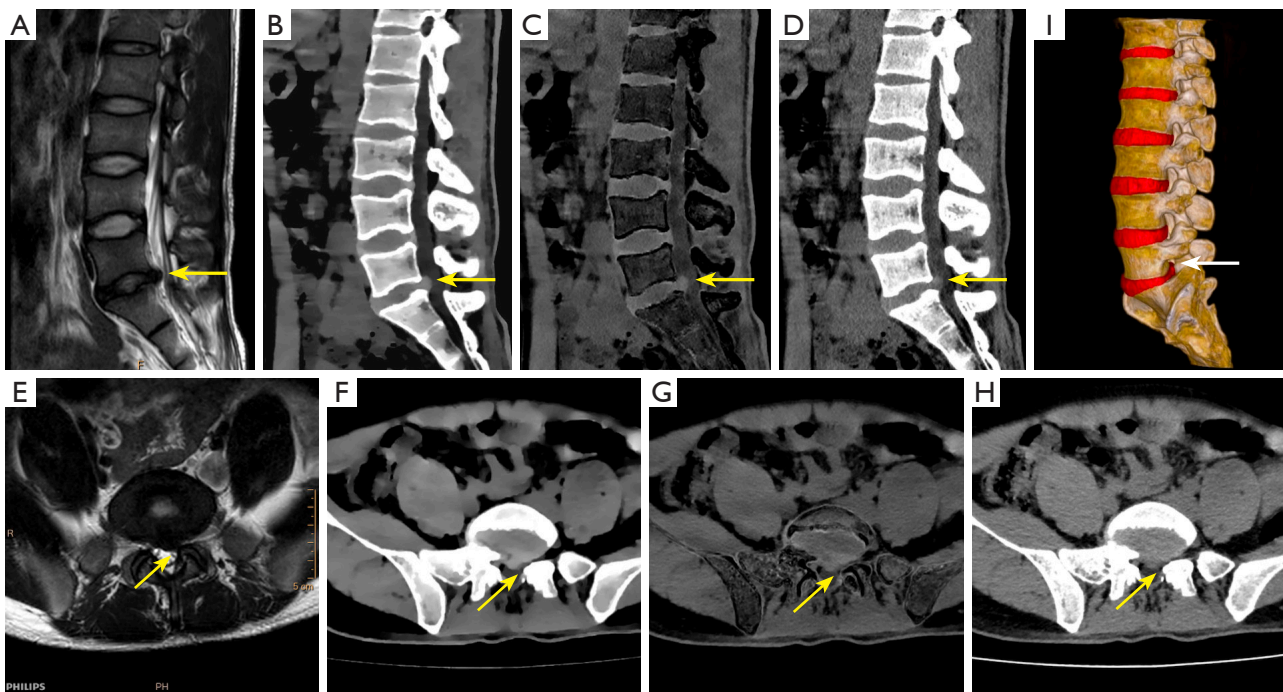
A 26-year-old male with lower back pain and paresthesia in the left lower leg. (A) Sagittal T2-weighted image showing lumbar disc protrusion at the L5/S1 level [yellow arrows in (A-D)]. (B) ED image providing clearer visualization of disc protrusion than (C) VNCa and (D) SC. (E) Axial T2-weighted images showing nerve root impingement [yellow arrows in (E-H)]. (F) ED providing clearer visualization than (G) VNCa and (H) SC. (I) A ED-VR showing foraminal stenosis on the left side (white arrow). ED, electron-density; VNCa, virtual noncalcium; SC, standard computed tomography; ED-VR, volume-rendering model generated from ED.
